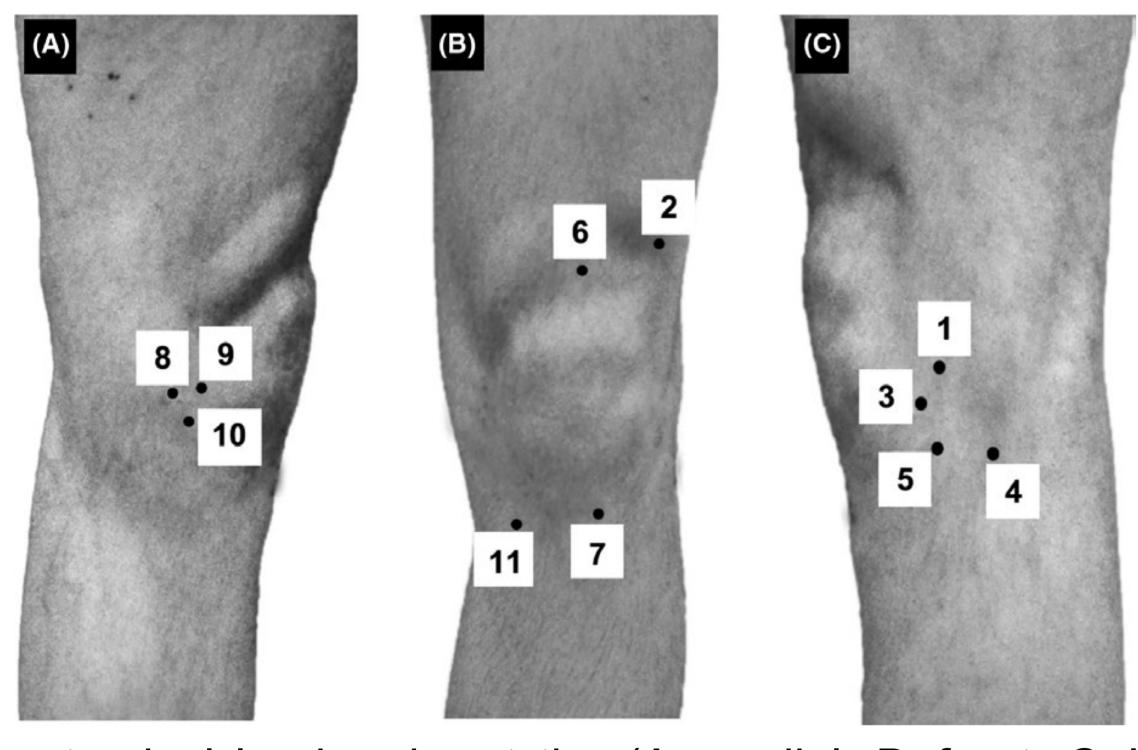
Anatomical landmarks at the (A=medial, B=front, C=lateral) knee for sonography and pressure pain threshold assessment. 1=lateral condyle of femur, 2=distal edge of m. vastus lateralis, 3=lateral knee joint space, 4=fibular head, 5=gerdy's tubercle, 6=suprapatellar region, 7=Infrapatellar area, 8=medial femur condyle, 9=medial knee joint space, 10=medial tibial plateau, 11=tibial metaphysis.
